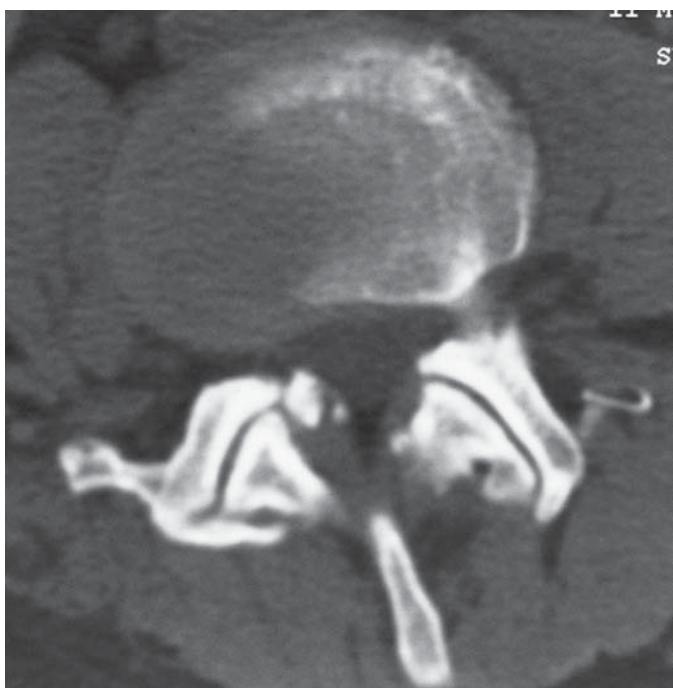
Axial CT image using bone window algorithm demonstrating degenerative hypertrophic facet joint changes at the L4 level in a symptomatic patient.
